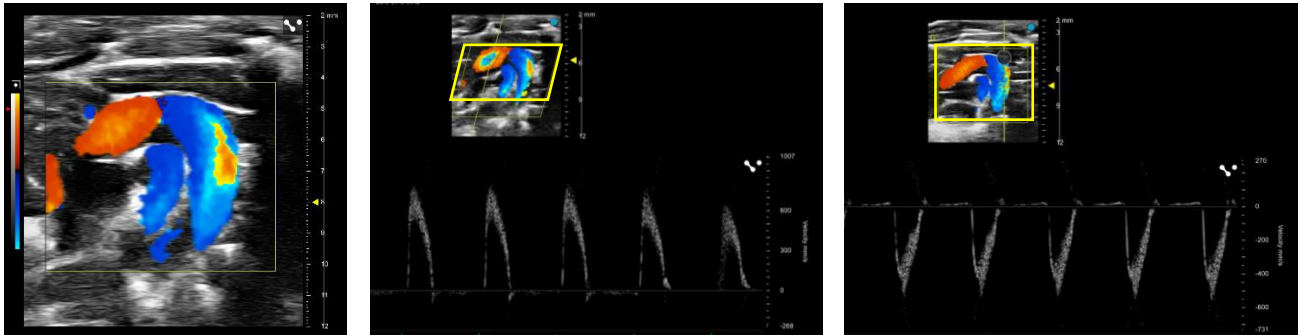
Color Doppler image of aortic arch (left), and PW Doppler of the ascending aorta blood flow velocity (middle) and descending aorta blood flow velocity (right). Beam steering has been implemented for the ascending aorta acquisition (indicated by the shift in color box shape) to reduce the Doppler angle by 15 degrees.
